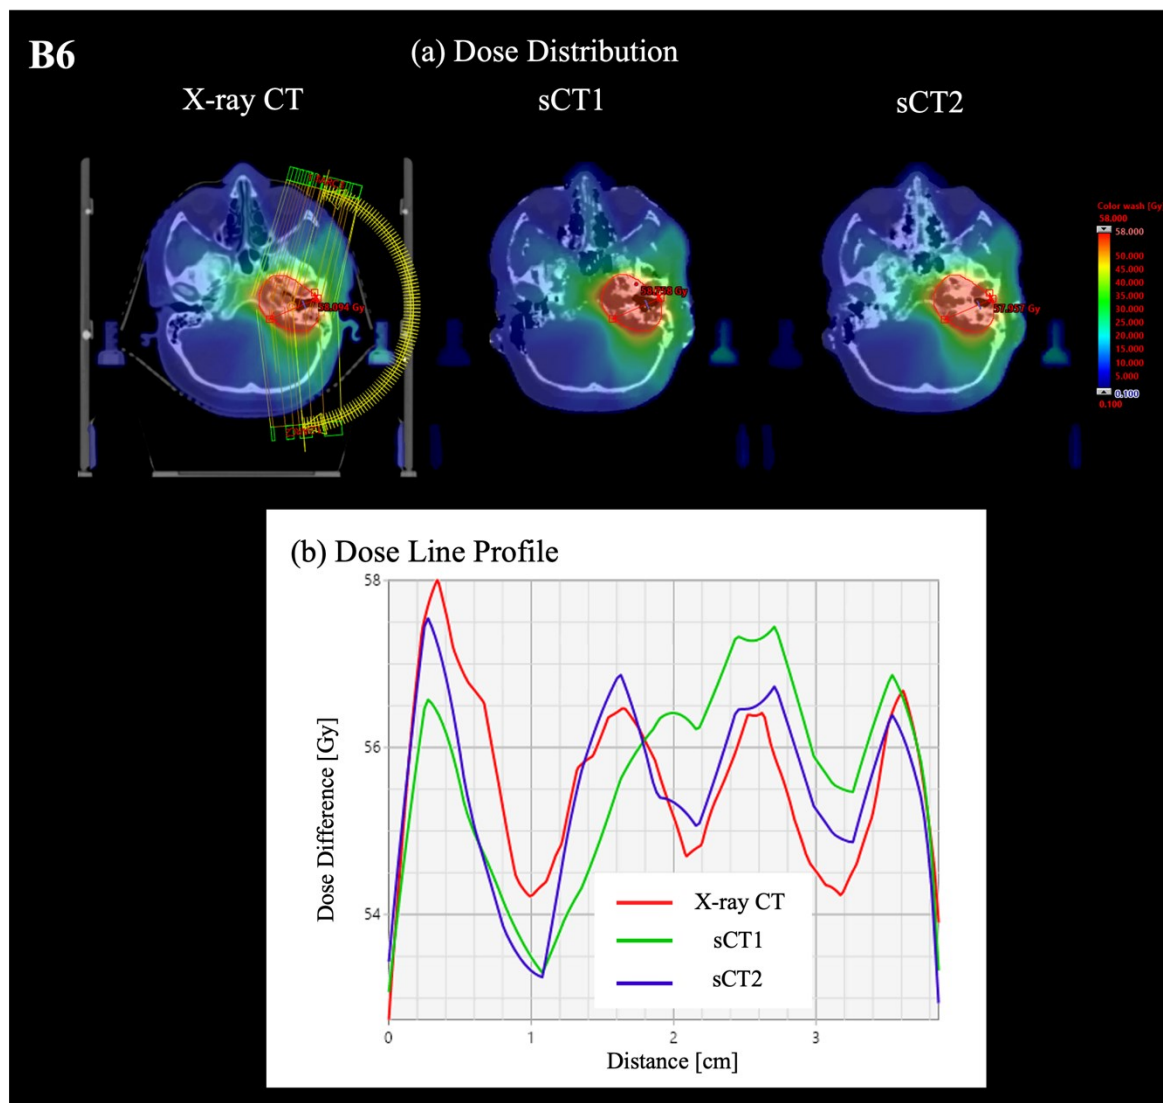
(a) Dose distributions of X-ray CT, sCT1, and sCT2 for patient B6. The PTV was located near the Eustachian tube, surrounded by complicated bone structures. (b) The dose line profile along a red line inside the PTV in the sCT and X-ray CT images.
